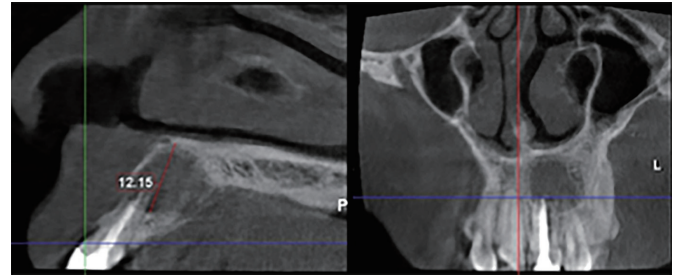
3D x-ray for maxillary left central incisor showing 12.15mm apical radiolucency and root resorption.
